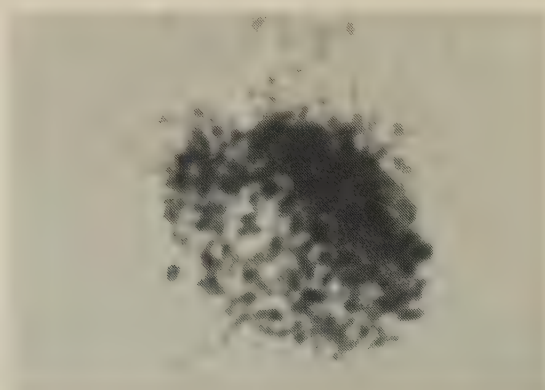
Same patient, same view. Stress scintigraphy reveals a drastically decreased radionuclide uptake in the area referable to the interventricular septum.
